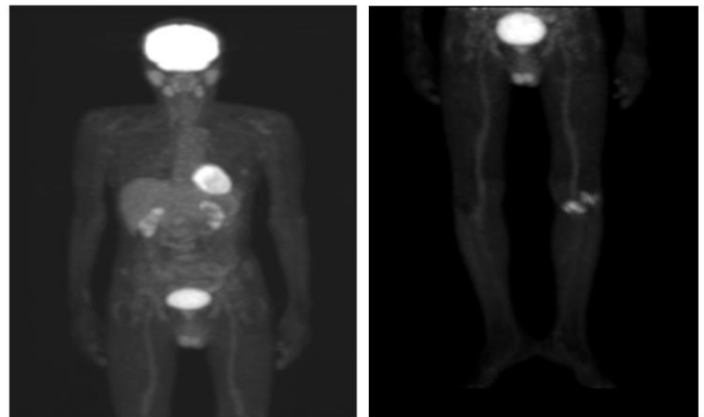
Whole body PET / CT with 18F-FDG, showing multiple lithic lesions in generalized bone marrow as well as in external lateral condyle and left tibial plateau with hypermetabolism associated with adjacent inflammatory changes.
